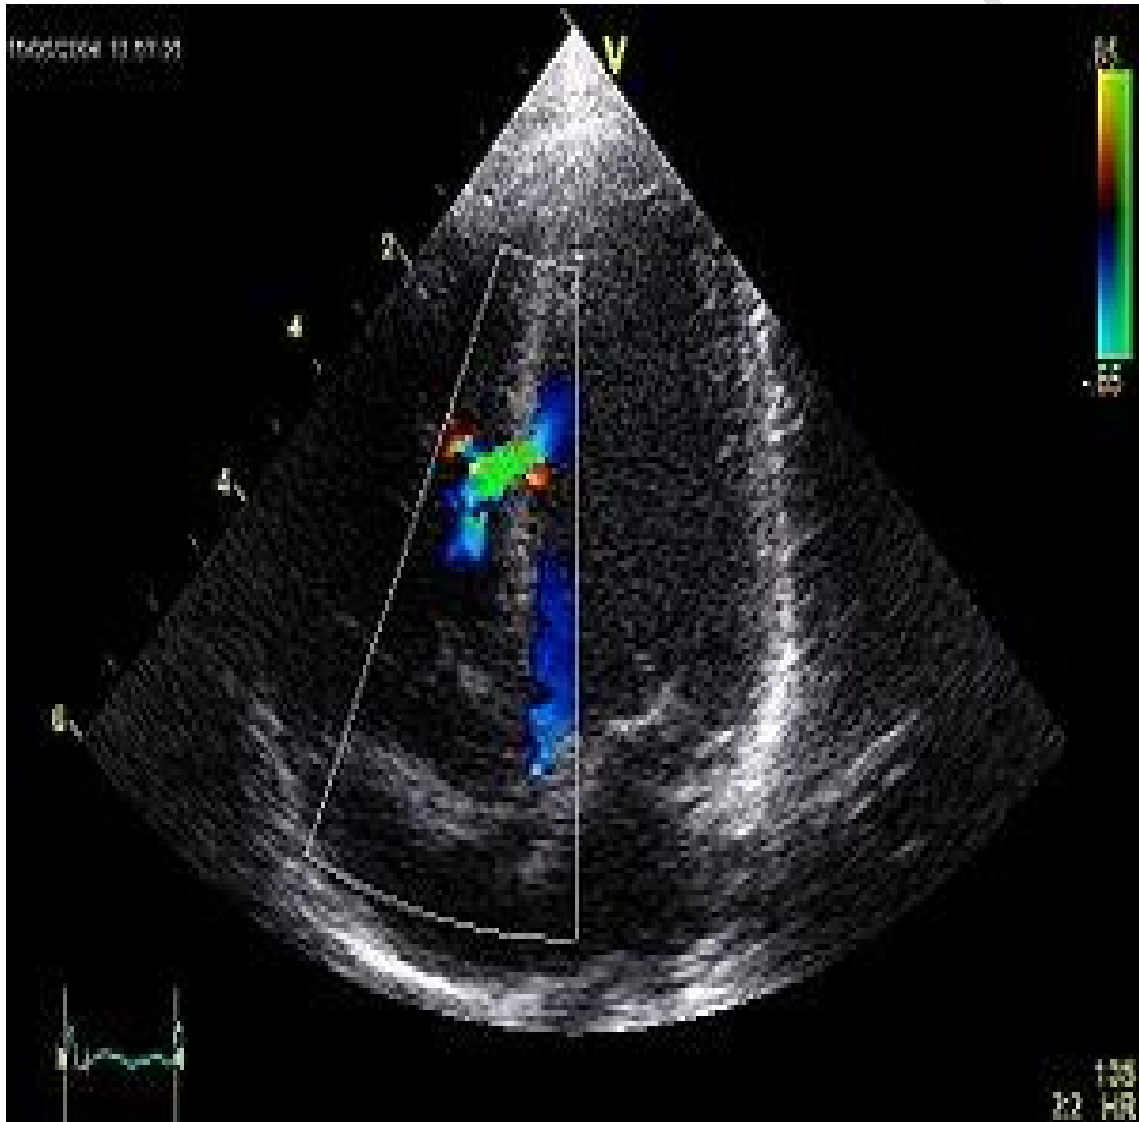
Apical 4 chamber view showing a rupture of the interventricular septum
